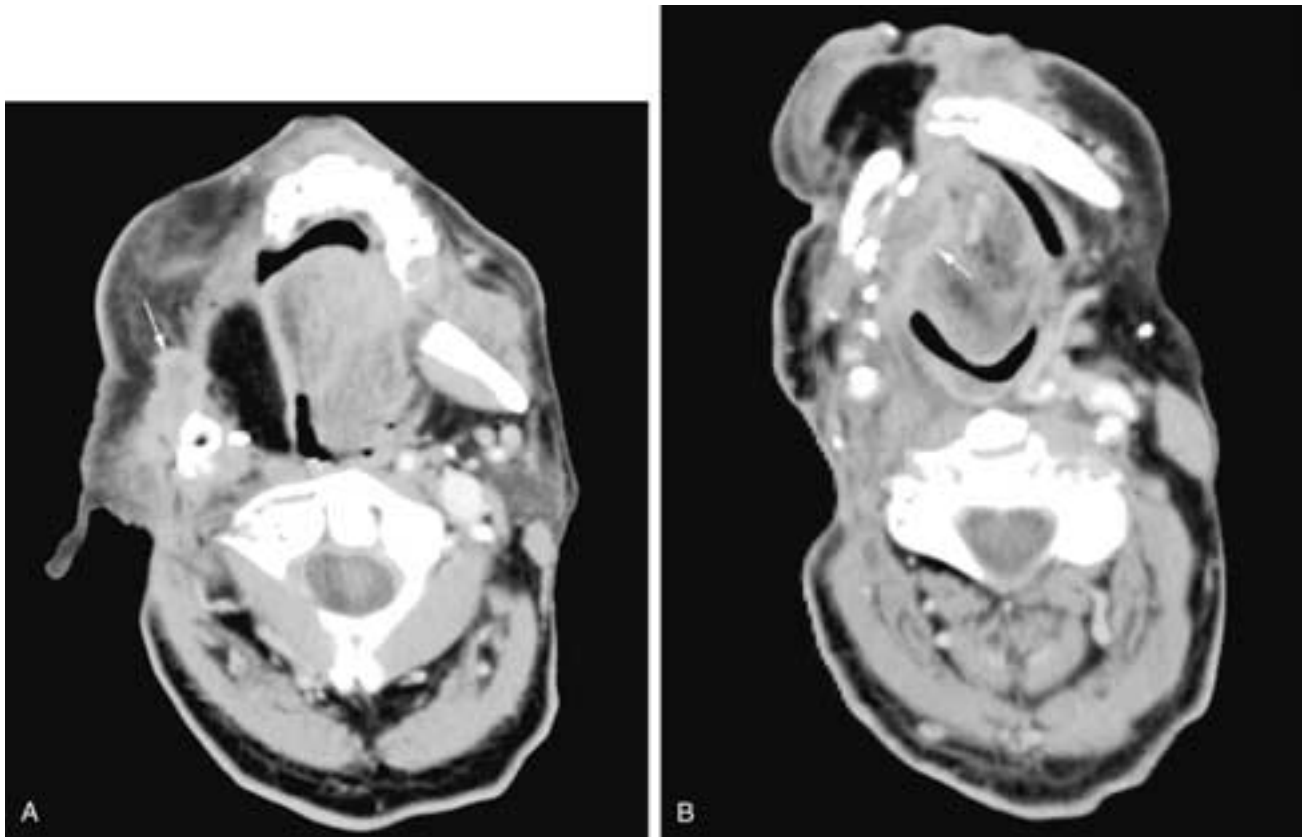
Axial contrast-enhanced CT scans from cranial (A) to caudal (B) on a patient who has had a right mandibulectomy with a flap reconstruction. This was a routine surveillance scan; the patient had no major symptoms. In A, there is a necrotic region within the flap (*arrow*) along the anterior aspect of the transplanted bone. In B, there is a necrotic area along the right anterior flap margin (*arrow*). This mass invaded the lower anterior tongue. Both areas were recurrent squamous cell carcinoma.
